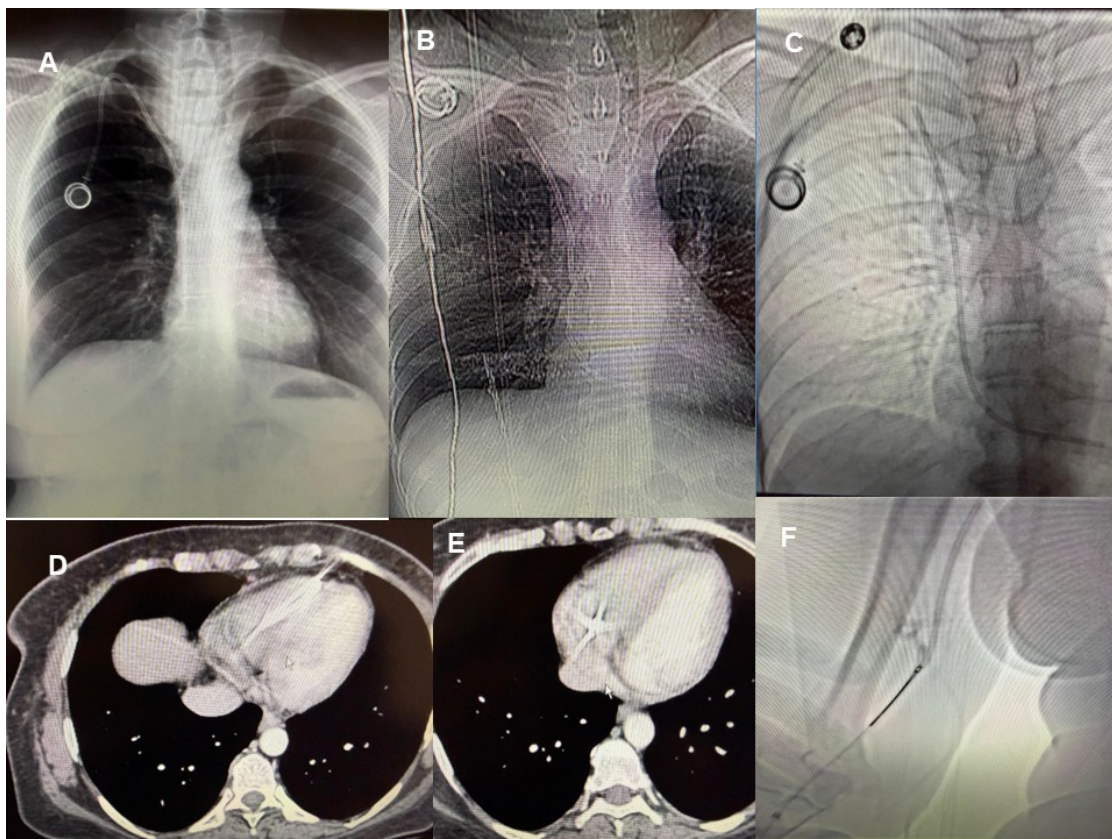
Radiological progression of an implantable port catheter showing implantation, acute rupture, and endovascular retrieval. A) Early Post-operative Control: The port catheter system, placed via the right subclavian vein, is shown with normal anatomical positioning and intact reservoir connection immediately following implantation. B) Computed Tomography (CT) – Disconnection View: Complete transection of the catheter is observed within the costoclavicular space (between the clavicle and the first rib), showing the proximal end disconnected from the reservoir. C) Posteroanterior Chest X-ray – Catheter Migration: The ruptured distal catheter fragment is seen migrating along the vascular track toward the cardiac chambers (right atrium and ventricle). D) CT Axial Section – Right Atrium: The embolized radiopaque catheter fragment is clearly visible within the right atrium. E) CT Axial Section – Right Ventricle: The distal tip of the catheter is shown extending into the right ventricle, passing through the tricuspid valve plane. F) Fluoroscopic Image – Endovascular Extraction: The retrieval process is depicted as a "snare" catheter, advanced via the right brachial vein, captures and extracts the embolized fragment.
